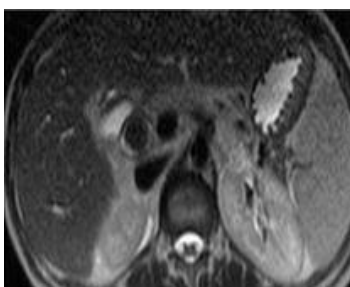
MRI - Calculus at the level of distal CBD seen as rounded hypo intensity within its lumen
